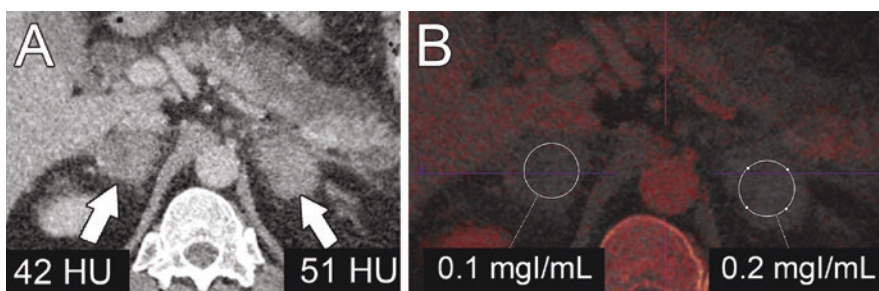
(a) Contrast-enhanced DECT of the adrenal glands in a patient in septic shock. Both lesions are hyperdense with CT attenuation values of about 50 HU. (b) Reconstructed iodine maps showed no relevant iodine
